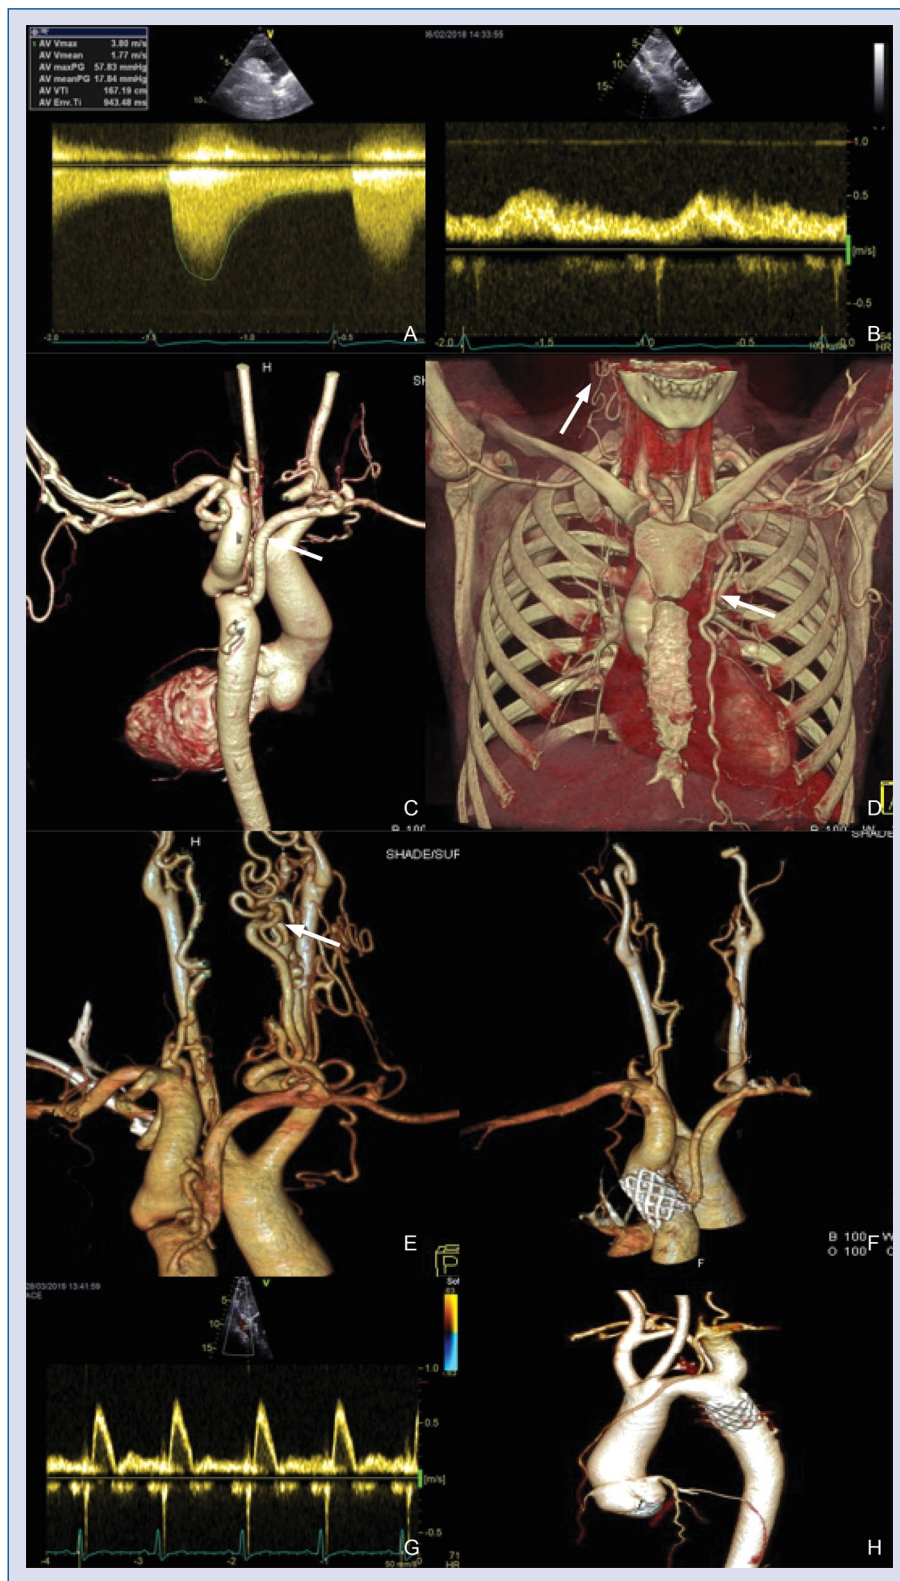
A. Continuous wave (CW) Doppler at coarctation site; B. CW Doppler in the abdominal aorta; C. Computed tomography angiography (CTA), posterior view — coarctation of the aorta, arteria lusoria (arrow); D. CTA — collateral circulation on the chest wall (left side — arrow) and in the neck (right side — arrow); E. CTA, posterior view — extensive asymmetrical collateral circulation on the neck (arrow); F. CTA after stent implantation (posterior view) — normal blood circulation on the neck; G. CW Doppler in abdominal aorta after coarctation treatment; H. CTA of thoracic aorta after stent placement.
